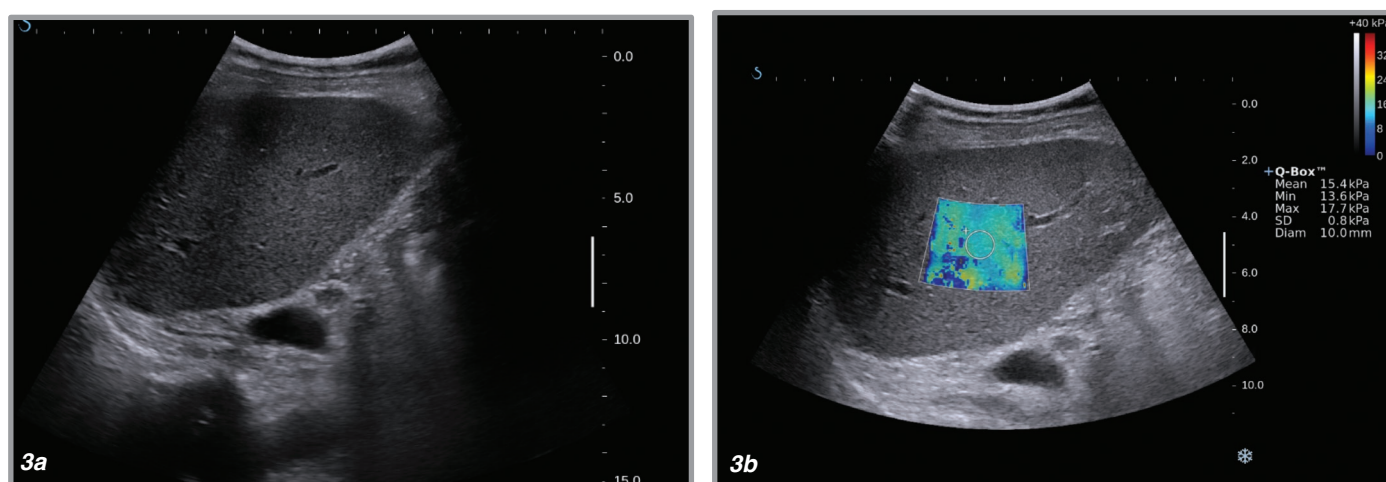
A 52 year-old man with chronic hepatitis. a. On B-mode ultrasound, coarse echotexture, an ultrasound feature representing chronic hepatitis. b. Mean elasticity was 15.4 kPa on ShearWave Elastography. Biopsy confirmed a METAVIR F3 liver fibrosis.
